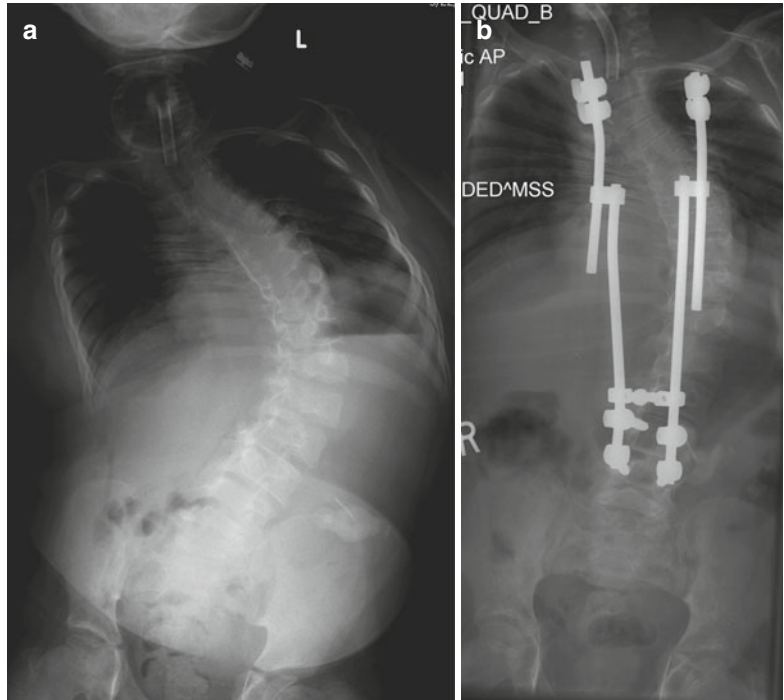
(a) Preoperative AP radiograph. (b) Postoperative unilateral growing rod. (c) Two years later, significant decompensation has occurred (Reproduced with permission of Children’s Orthopaedic Center, Los Angeles)
